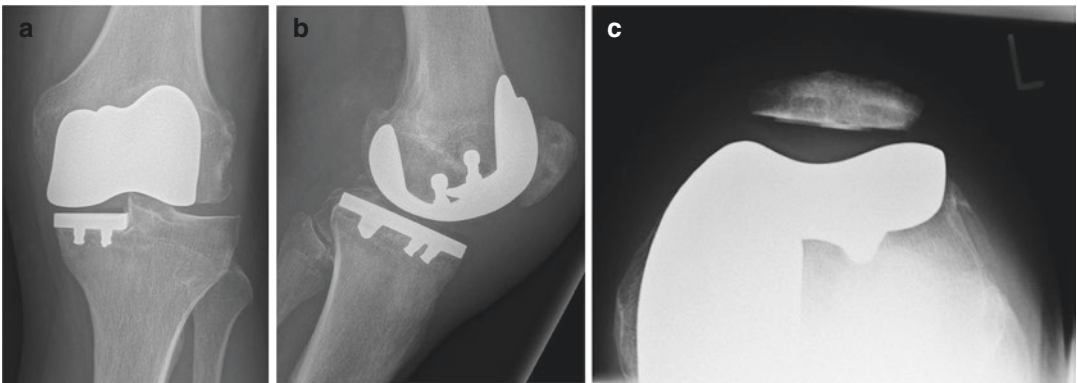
(a–c) Postoperative radiographs after implantation of the monolithic customized bicompartamental arthroplasty (anteroposterior (a), lateral (b), Merchant view (c)) of the case presented in Fig. 7.1
